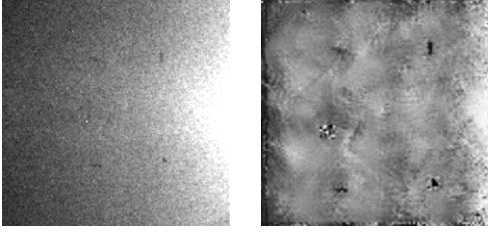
X-ray fluoroscopy image with markers before (left) and after (right) pre-processing. Applying denoising and CLAHE results in enhanced clarity and easily distinguishable markers.
